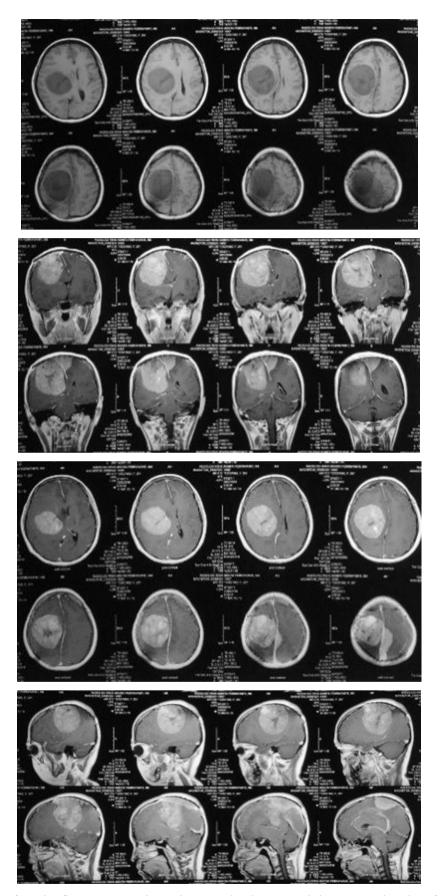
MRI 1 year after the first surgery showed a massive intracranial mass at the site of the previous tumor.
